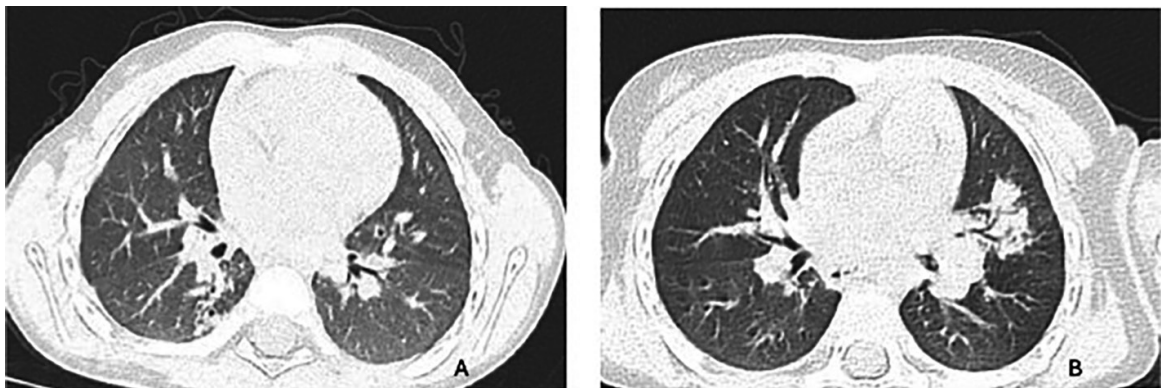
Image A: Chest CT scan for case 3 shows multiple calcified nodular images in the posterior segment of the right lower lobe. There is also a patchy dense area with bronchiectasis. Image B: Chest CT scan for case 4 shows left hilar lymph node enlargement and patchy consolidation of the lung parenchyma with air bronchogram in the lingula.
